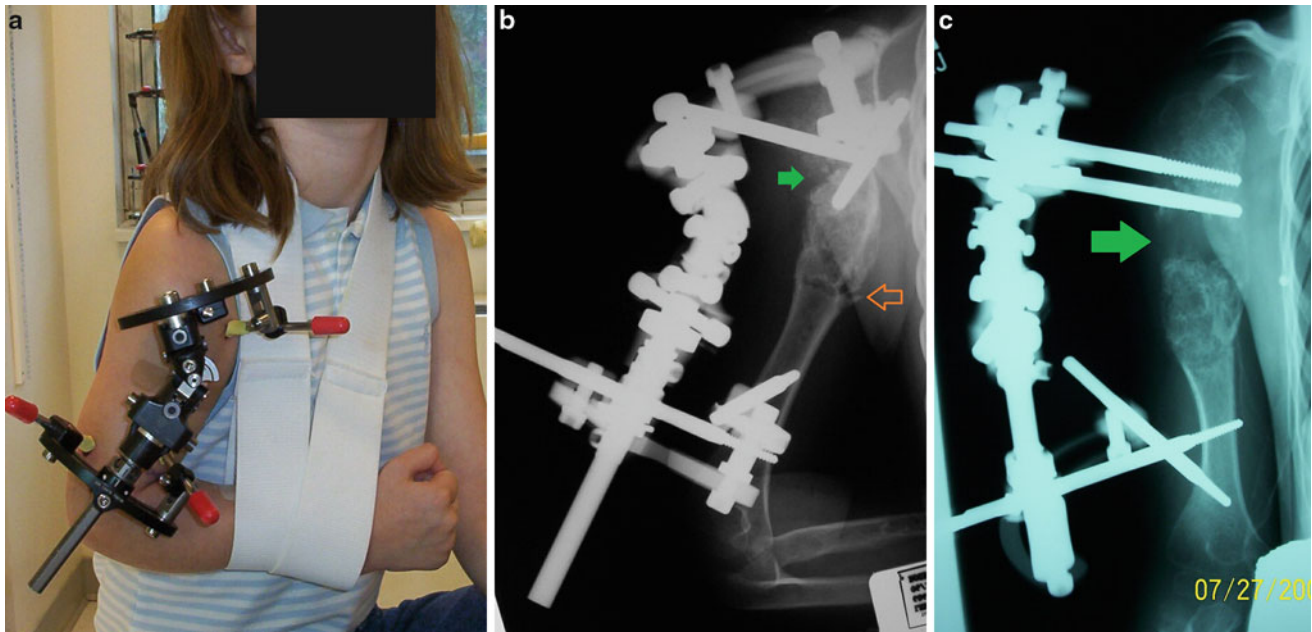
(a) Early postoperative clinical picture showing how the frame mimics the deformity. Note the hinge at the level of the deformity. (b) Lateral X-ray showing fracture in the proximal humerus (*green arrow*)
